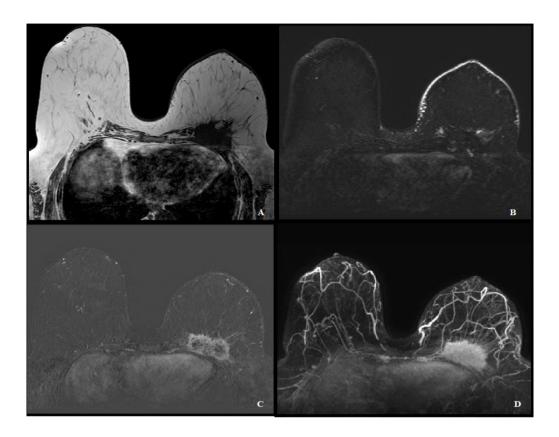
MRI was performed that showed an irregular, spiculated, contrast-enhanced mass, invading chest wall, including the 4th e 5th left ribs, measuring 8,0 x 7,0 x 4,5 cm, in the posterior third of the central area of the left breast, BI-RADS® 5 (highly suggestive of maligancy). A) Hypointense mass at T1-weighted. B) Edema and thickening skin, which may represent post-surgical and post-actinic changes on the left breast. Hypointense mass in T2-weighted. C) Mass in the left breast showing heterogeneous contrast enhancement. Some areas do not impregnate contrast and may represent a necrotic component. D) Maximal intensity projection (MIP) image from contrast-enhanced MRI shows an irregular and piculated mass.
